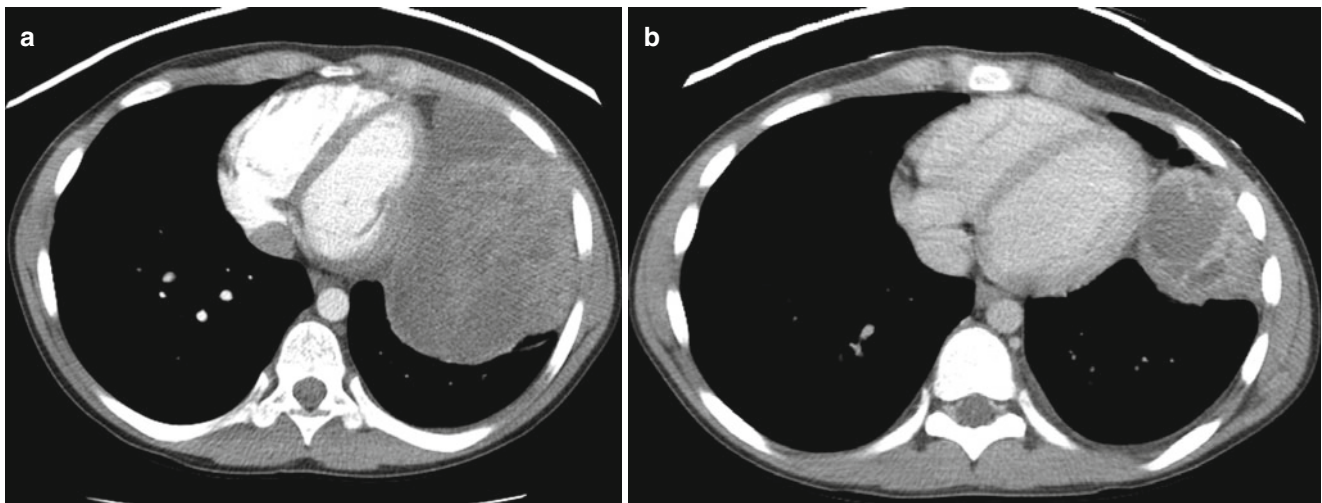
This 10 year old boy presented with left-sided chest pain several days after falling from a tree. Chest radiograph was read as a pulmonary contusion. He had two other episodes of chest pain subsequently and radiographs were felt to demonstrate pneumonias. Six months later a chest radiograph and (a) CT scan demonstrated a chest
